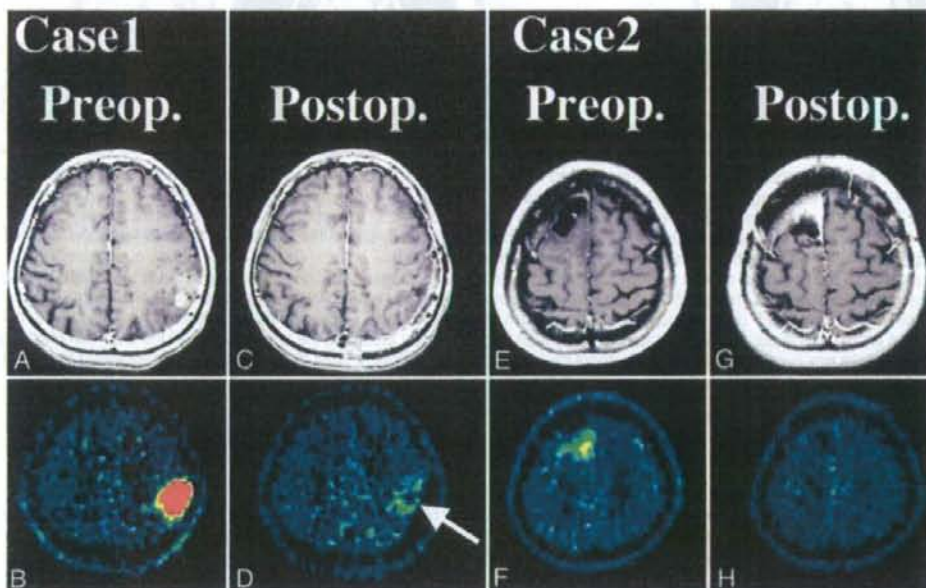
Cases 1 (A–D) and 2 (E–H). A–D: Images obtained in a 40-year-old man with a left parietal glioblastoma multiforme resected using the conventional navigation system. Preoperative MR (A) and MET-PET (B) images. Postoperative MR image (C) showing total disappearance of the Gd-enhanced mass lesion, whereas the MET-PET image (D) reveals the residual lesion with elevated MET uptake (arrow). E–H: Images obtained in a 38-year-old woman with a right frontal oligodendroglioma. The patient had undergone an initial surgery, with presumed total tumor removal, at another hospital. However, the MET-PET images at admission to our hospital clearly demonstrated an area with elevated MET uptake (E and F). Postoperative imaging after a second surgery using multimodal navigation revealed no evidence of remnant tumor (G and H).
